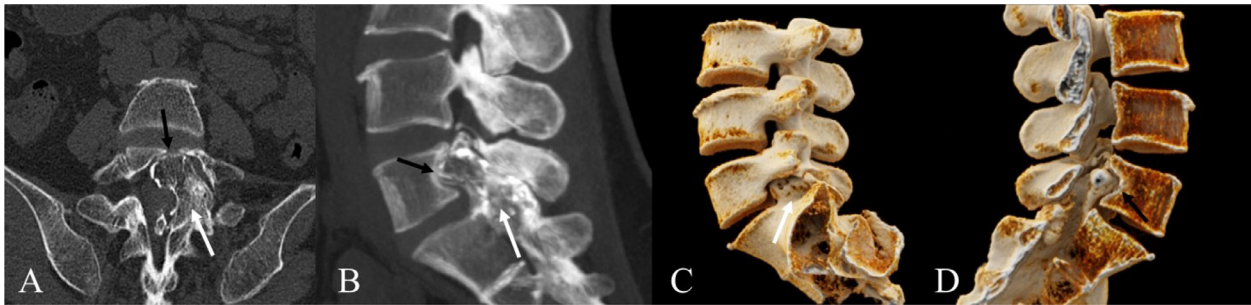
(A–D) Oblique Axial CT and MIP (A, B) showed bony prominences growing along the left lamina of left S1 (white arrow) causing compressive bony resorption of the L5 vertebral body (black arrow). Cinematic rendering (C, D) showed the lesion originated from the left lamina of S1 (white arrow) compressing the L5 vertebral body (black arrow) causing stenosis of the left intervertebral foramen.
